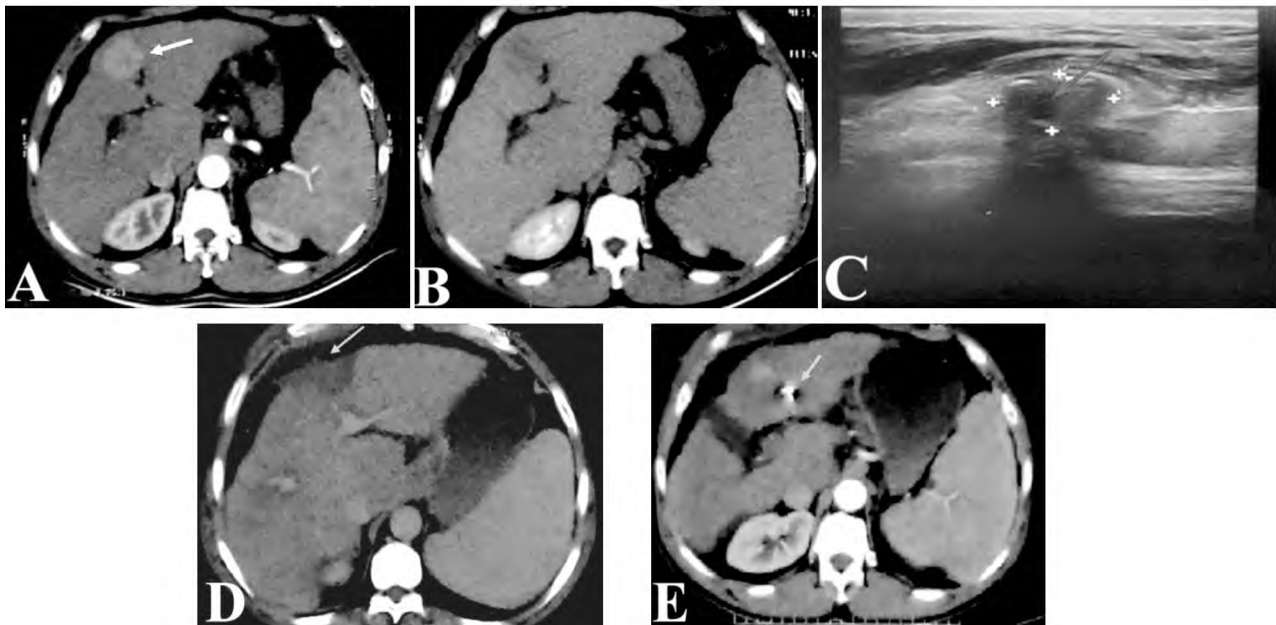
A male patient aged 49 years old with hepatitis C cirrhosis complicated by left liver lobe HCC detected by triphasic CT examination. (A&B): Triphasic CT abdomen (A) arterial (yellow arrow). (B) Delayed (red arrow) showing a well defined focal lesion in the left liver lobe segment IV measuring 5 x 5cm, with arterial enhancement and rapid washout in portal phases characteristic of HCC. (C): Ultrasound shows peri-hepatic collection related to the site of previous MWA near segment IV (blue arrow). (D): Triphasic CT shows peri-hepatic collection near the site of the previous ablation at segment IV (orange arrow). (E): Triphasic CT shows evidence of MWA needle tip fracture (Green arrow).
